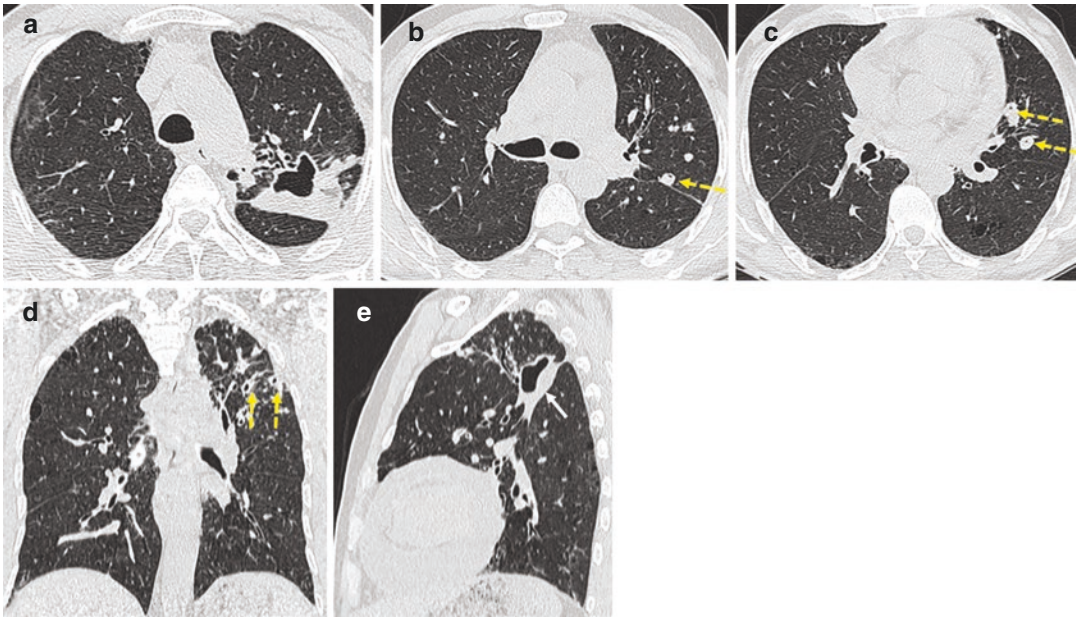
Multidrug-resistant tuberculosis in a 54-year-old patient. (a–c) Axial, (d) coronal, and (e) sagittal CT images show a cavitating consolidation (white arrow) and nodules located mainly in the left upper lung (yellow arrows)
